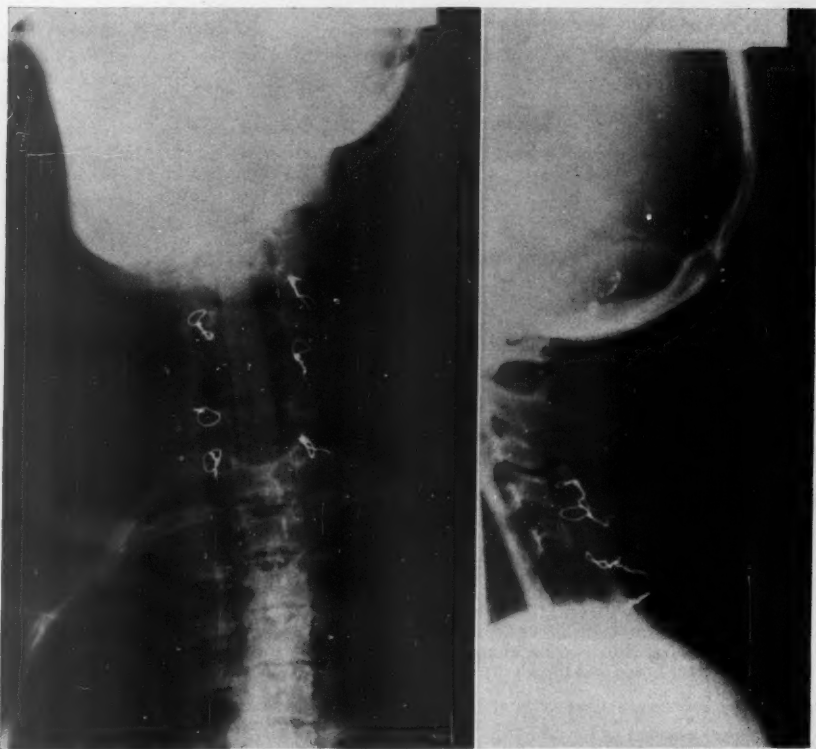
Case 5.* Postoperative x-rays showing the posterior bilateral iliac bone struts attached to the facet joints by wire loops at the time of the laminectomy and the anterior tibial bone strut running from C-3 to T-1 placed anteriorly at the second operation when the body of C-6, which was almost entirely replaced by neurofibrosarcoma, was excised.
